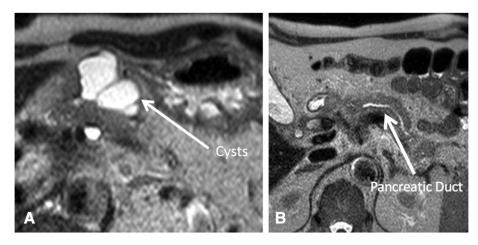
A: Visualization of cystic areas (A) and pancreatic duct (B) on T2-weighted imaging at 1.5 T.
